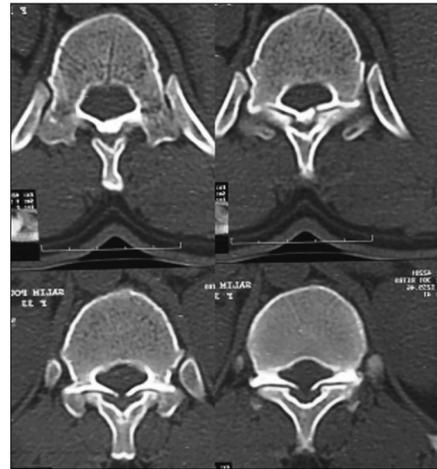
CT scan, axial views at T10-T11 level shows bilateral fused type ossification of the ligamentum flavum.
